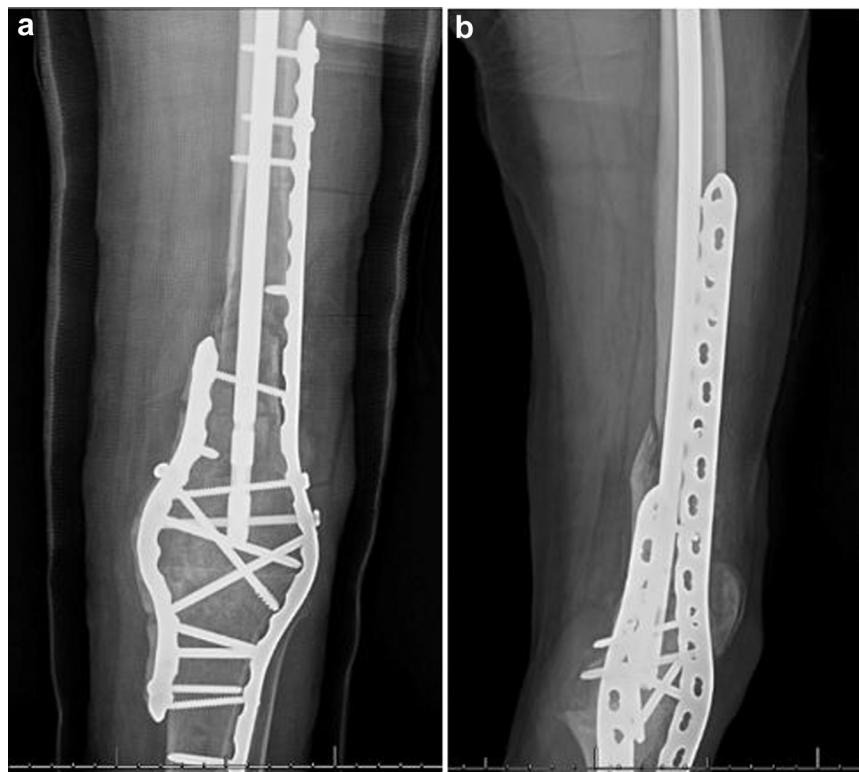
Postoperative revision plating and IMN radiographs. Anteroposterior (a) and lateral (b) radiographs after revision of the lateral plate to a 22-hole large fragment plate with additional intramedullary nail fixation.
